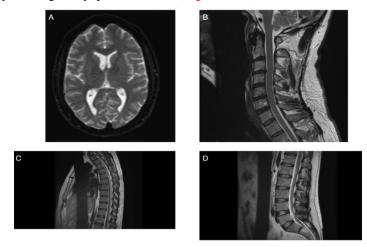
Unremarkable contrast enhanced magnetic resonance imaging of the brain, cervical spine, thoracic spine, and lumbar spine
